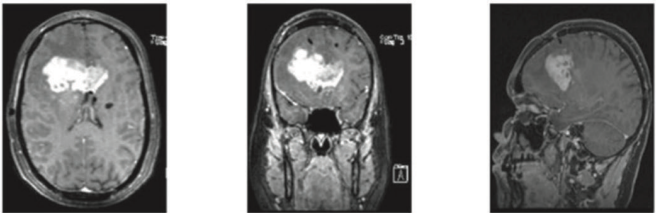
Vignette of case 1 with specialty-specific answers on the question ‘Would you recommend a re-resection in this case?’ and underlying considerations. MRI images shown are T1-weighted images after contrast administration.
